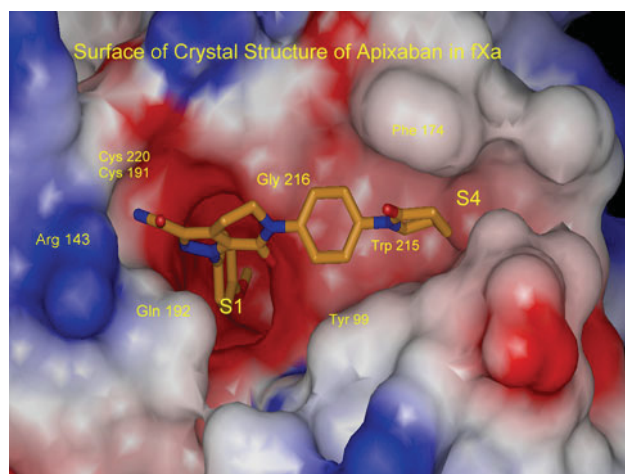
X-ray structure of apixaban bound to factor Xa
